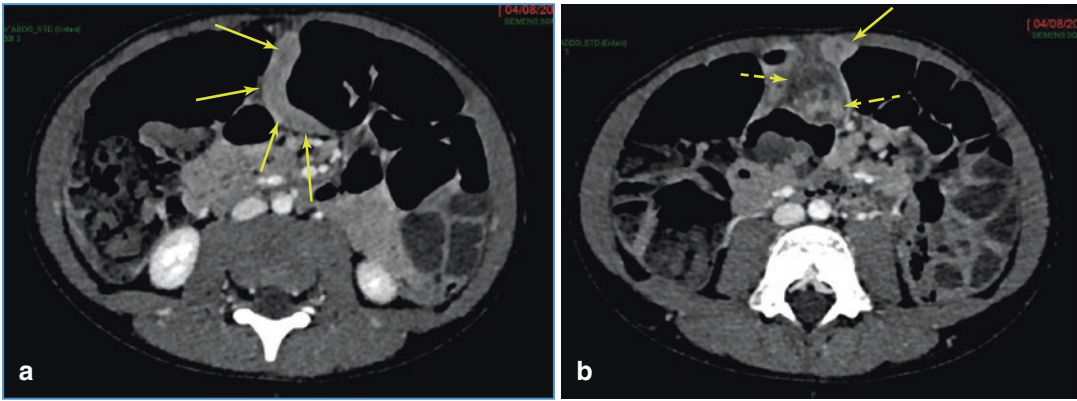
Diverticulitis in a 7-year-old boy explored on CE-CT. (a) An inflamed tubular bowel structure is present on the midline (yellow arrows). (b) The tubular structure
